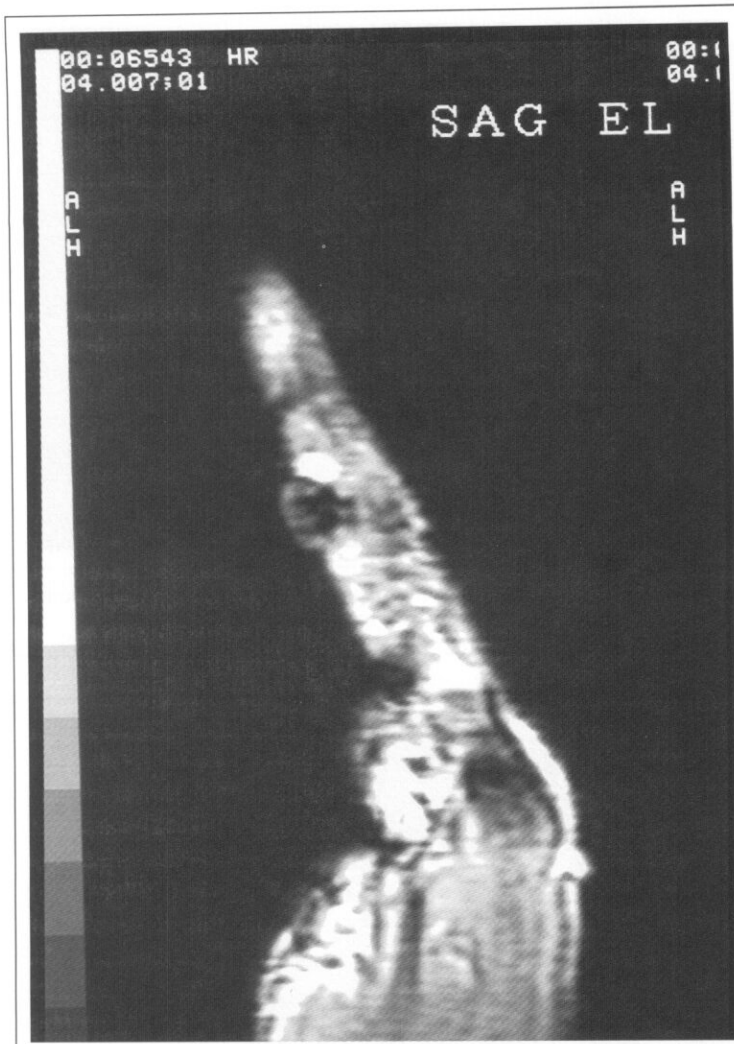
Magnetic resonance image of the finger demonstrating a bright lesion next to the solid mass on T2-weighted sagittal images. This is suggestive of a cyst.
